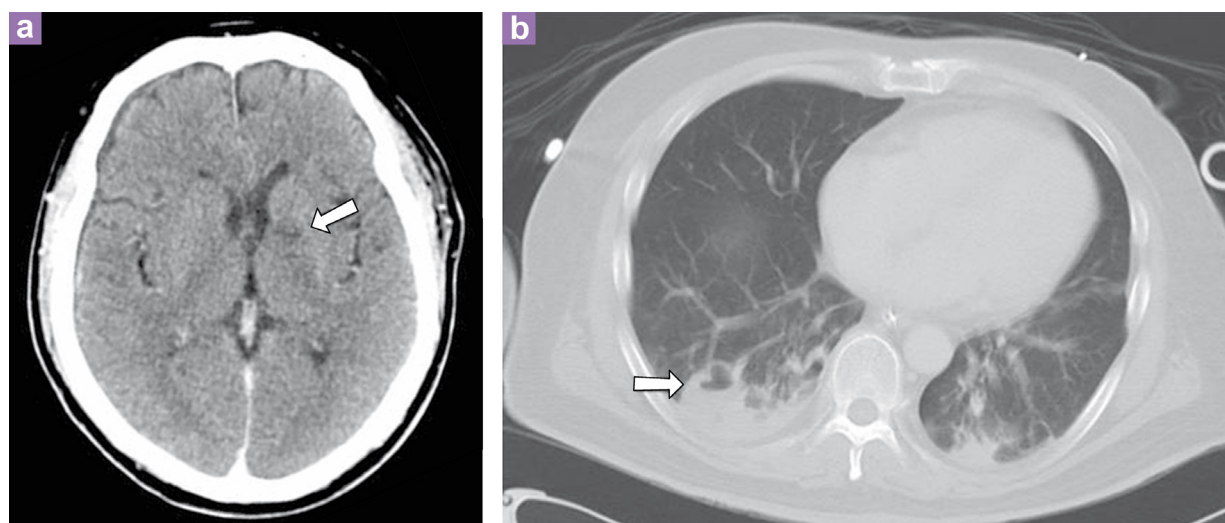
(a) Contrast-enhanced CT brain image showing non-enhancing hypodensity at the genu of the left internal capsule, which could be an infarct or a septic emboli (arrow). (b) Contrast-enhanced CT thorax showing lung nodules and consolidation, which showed cavitation with air–fluid level (arrow).
